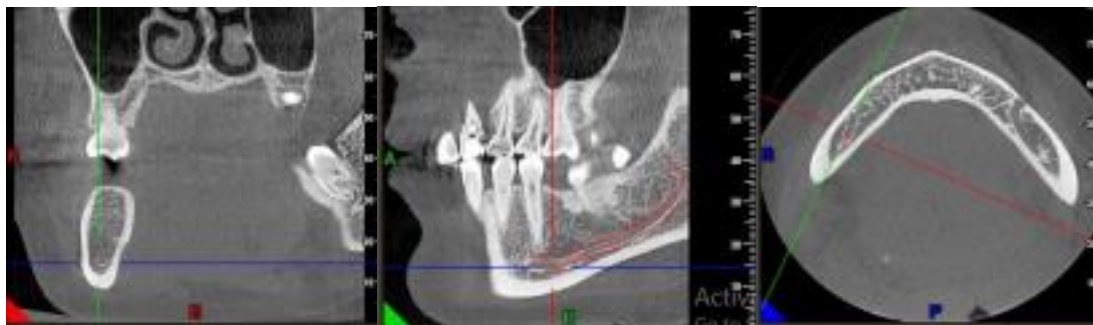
Sections of CBCT showing accessory mandibular canal 1 Axial, 2 Coronal, 3 Sagittal.
